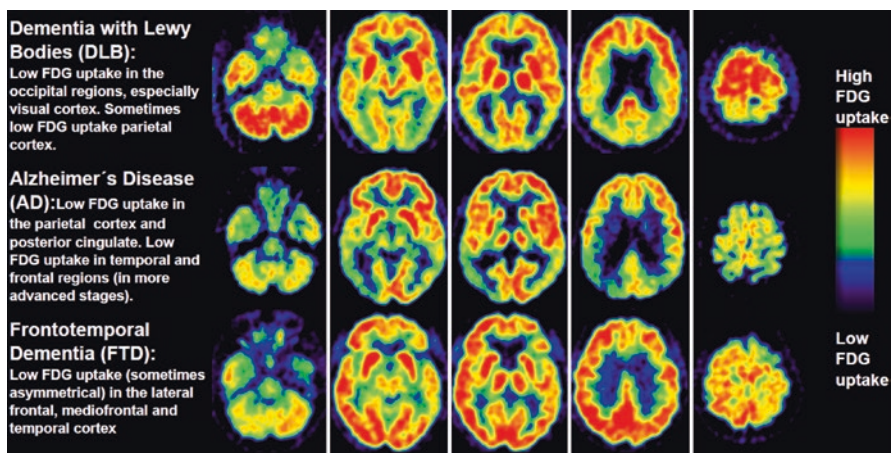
[^{18}F]-FDG-PET in different types of dementia: DLB, AD and FTD (Teune et al. 2010)
